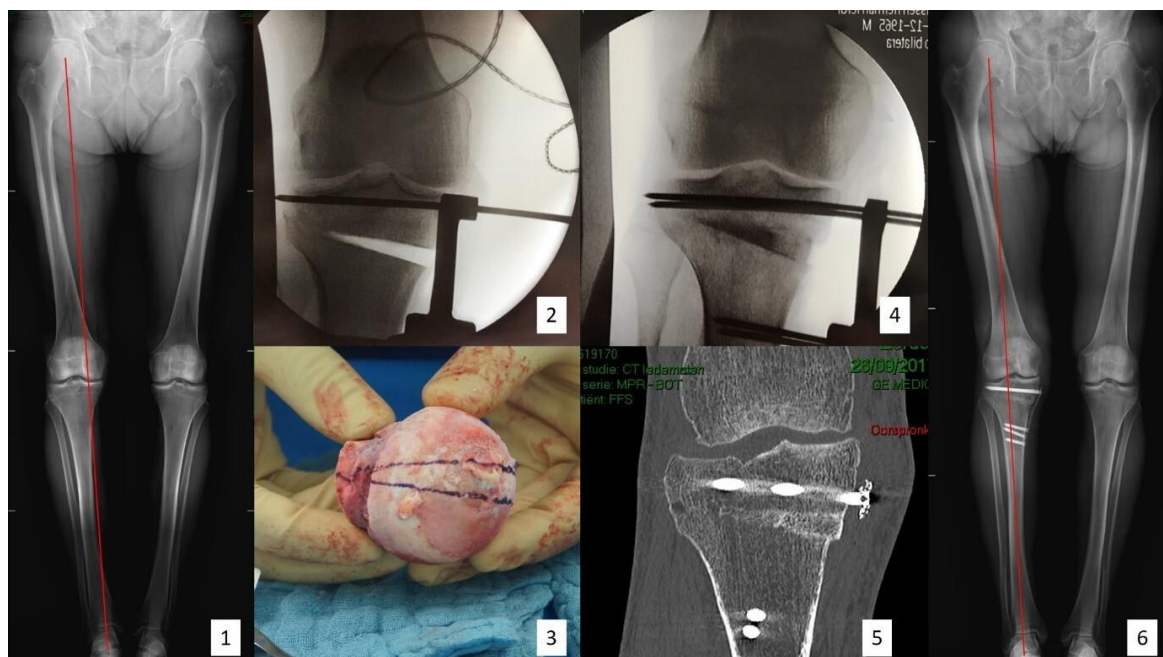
1) Full leg standing x-ray with the weight bearing line (WBL) crossing the medial compartment compatible with varus alignment 2) Peroperative fluoroscopy image showing the opening wedge osteotomy 3) Typical fresh frozen femoral head allograft with patient-specific osteotomy wedge dimensions delineated with ink marker 4) Peroperative fluoroscopy image of the same patient after impaction of the custom-cut triangular bone allograft into the osteotomy gap 5) Post-operative CT-scan showing complete osseointegration of the structural bone graft in the osteotomy gap 3 months after surgery 6) Post-operative full leg standing x-ray with the WBL crossing the lateral tibial spine indicating adequate realignment of the mechanical axis of the leg after HTO surgery.
